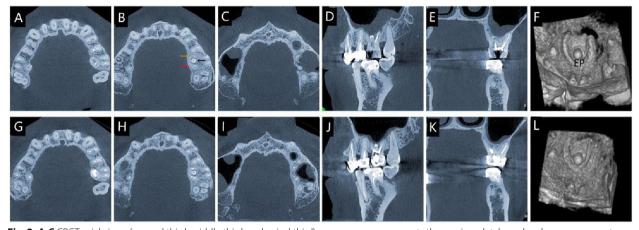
A-C CBCT axial views (coronal third, middle third, and apical third), orange arrow represents the mesio-palatal canal; red arrow represents the palatal canal; D-E CBCT sagittal and coronal view: left maxillary sinus membrane thickening; F The 3D reconstruction of tooth #26 showing periodontal bone loss; G-I One-year recall CBCT axial views (coronal third, middle third, and apical third); J-K One year recall CBCT sagittal and coronal view: left maxillary sinus membrane recent to normal level; L The one year recall 3D reconstruction of #26 showing periodontal bone renew
